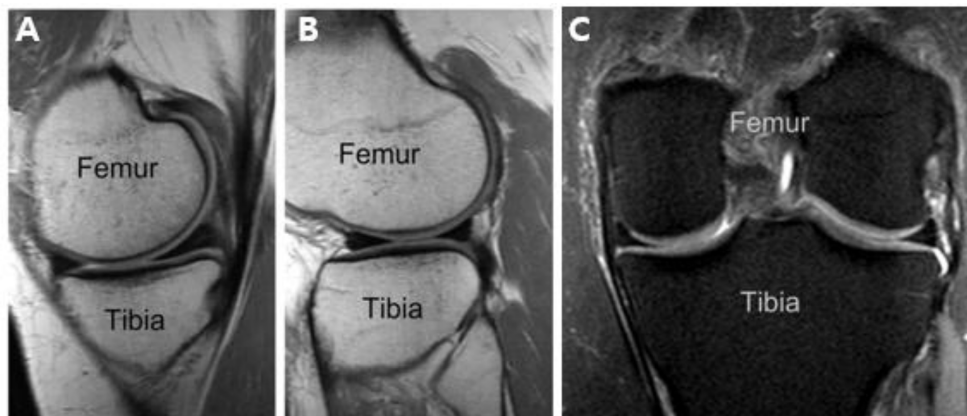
Normal Meniscus on MRI. (A) Medial meniscus with Sagittal T2WI view (B) Lateral meniscus with Sagittal T2WI view (C) Medial meniscus(left) and Lateral meniscus(right) with Coronal PD fat sat view.
